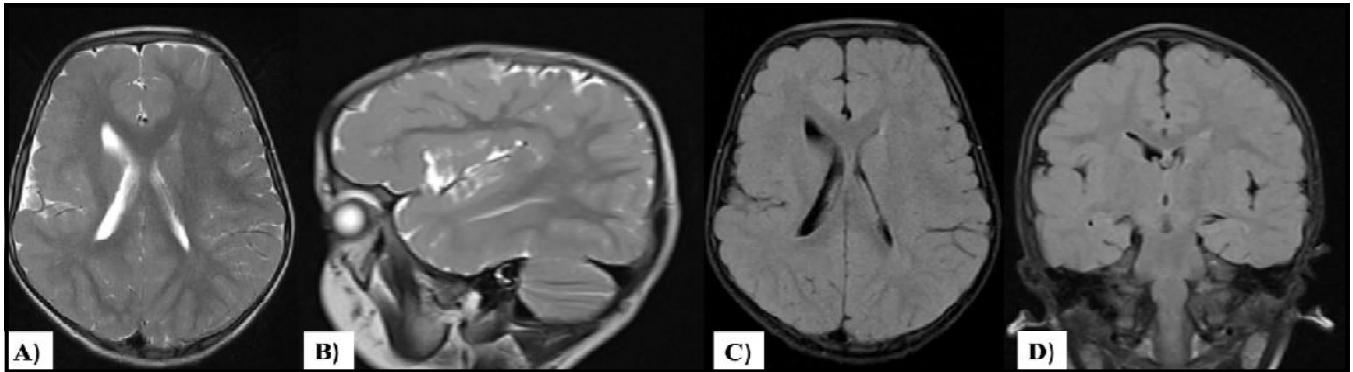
Unilateral Perisylvian Syndrome; Axial and Sagittal T2W (A, B) and Axial and Coronal FLAIR (C, D) images reveal right perisylvian polymicrogyria with widened sylvian fissure
